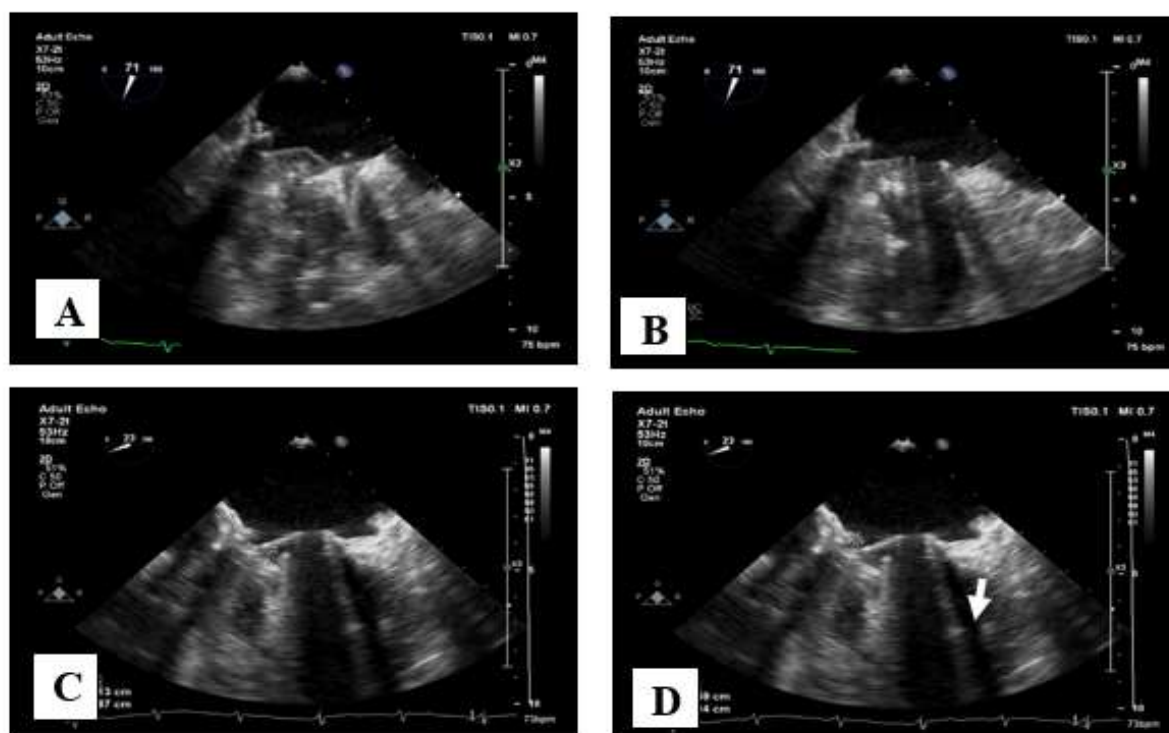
Pre-pump (cardiopulmonary bypass) intraoperative transesophageal echocardiography. A) Prosthetic MV in systole (both leaflets closed) B) Prosthetic MV in diastole - fixed medial leaflet (white arrow). C) Large immobile clot (1.1*0.5cm) entrapped in the medial hinge point of the medial leaflet. D) Smaller semi-mobile clot (0.3*0.35cm) on the atrial side of the mentioned hinge point.
